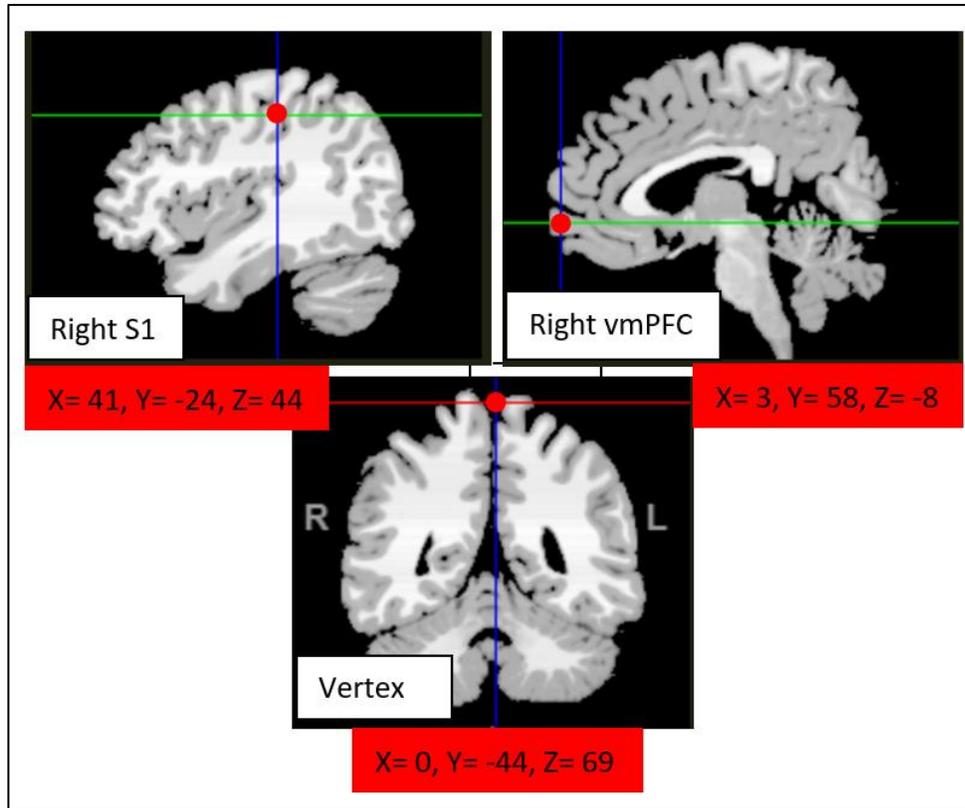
Visual depiction using MRI imaging of the location of each of the three brain regions: right vmPFC, S1 and Vertex. The red dots indicate the position the coil was place on participants' scalp. All coordinates are converted to Talairach.
